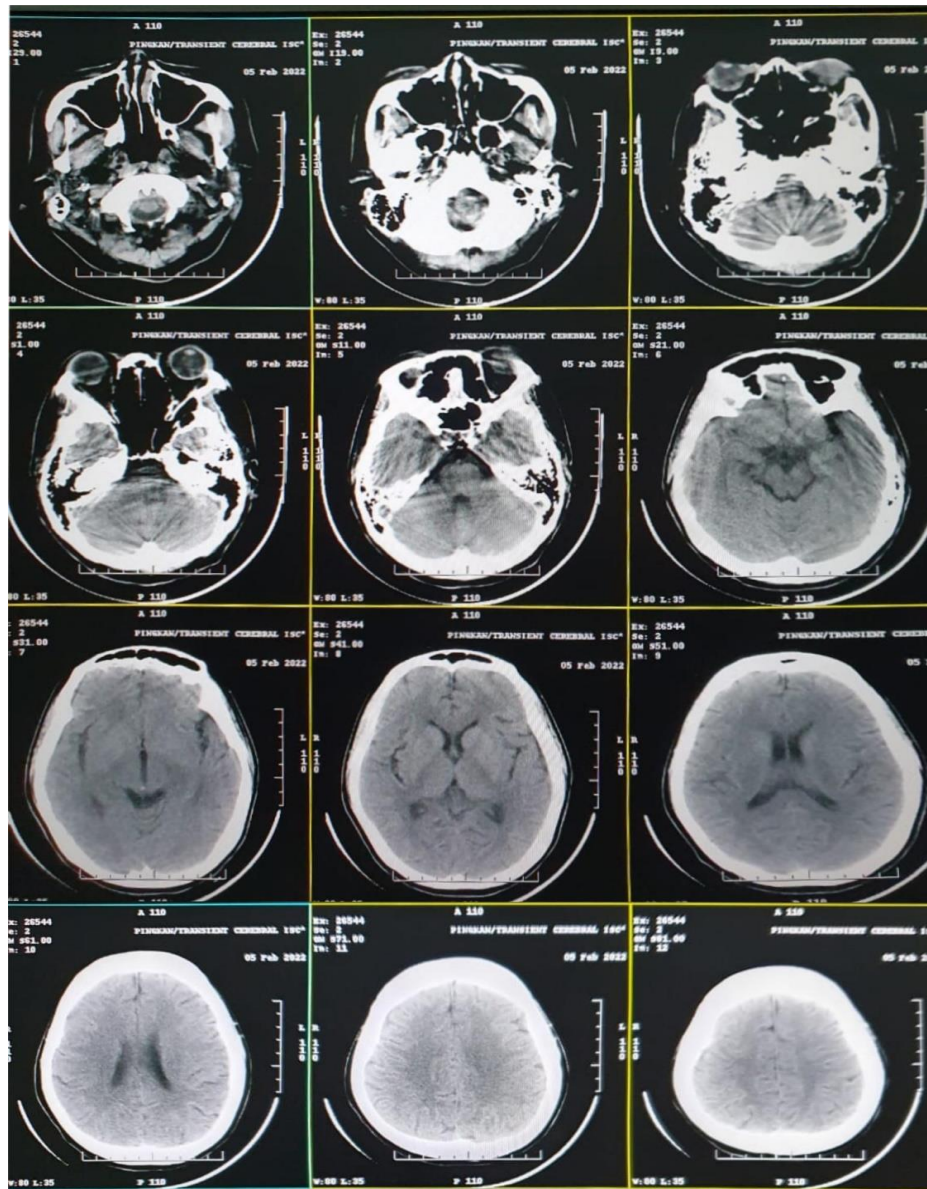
Non contrast Head CT Scan
